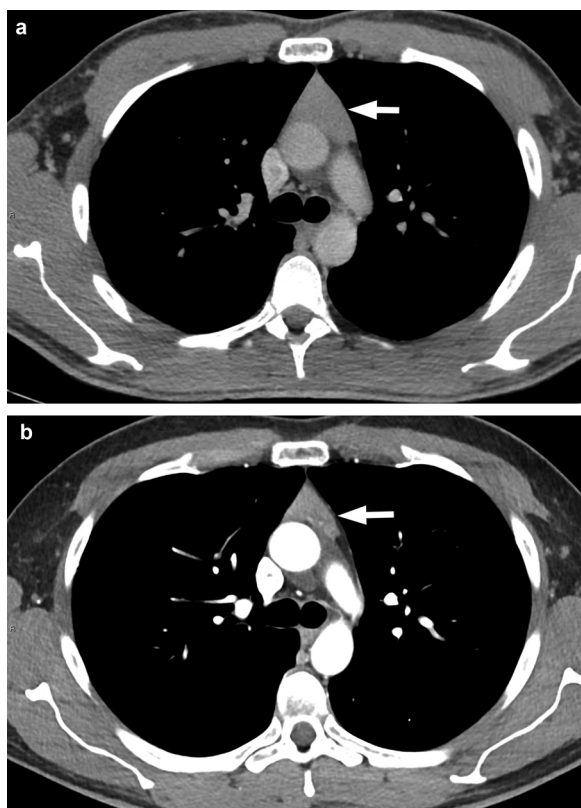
(A) Contrast-enhanced CT of the chest at the time of presentation showed an anterior mediastinal mass (white arrow), initially read as possible lymphoma or thymic mass at outside hospital. (B) Contrast-enhanced CT of the chest performed 4 months following resection of the GH-secreting pituitary macroadenoma showed decreased size of this triangular-shaped well-demarcated anterior mediastinal mass (white arrow), consistent with decreasing thymic hyperplasia.
